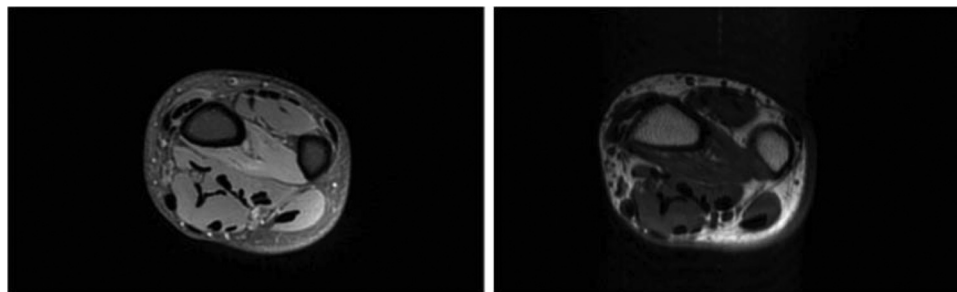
Non-contrast MR images of the distal forearm: axial T1WI demonstrates few streaks of high SI seen within the pronator quadratus muscle and axial fat-saturated proton density image demonstrating diffuse increased SI of the pronator quadratus muscle. Both images denote mild atrophy.
